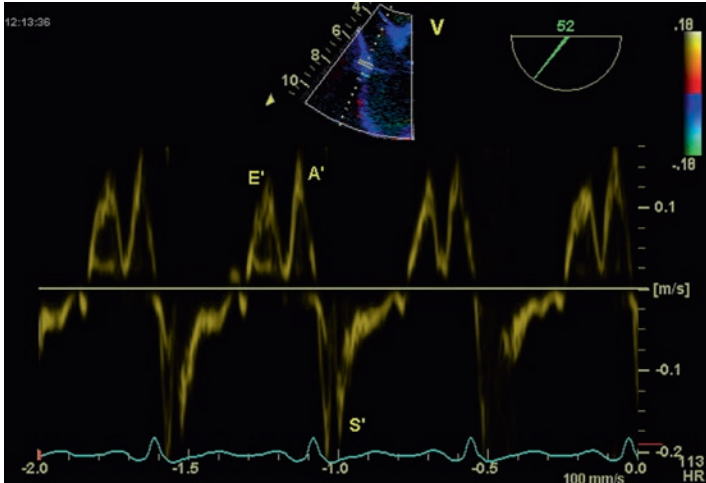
Doppler tissue imaging of the tricuspid annulus from the mid esophageal 4 chambers view. Early (E') and late (A') diastolic velocities and systolic (S') velocity labeled.
